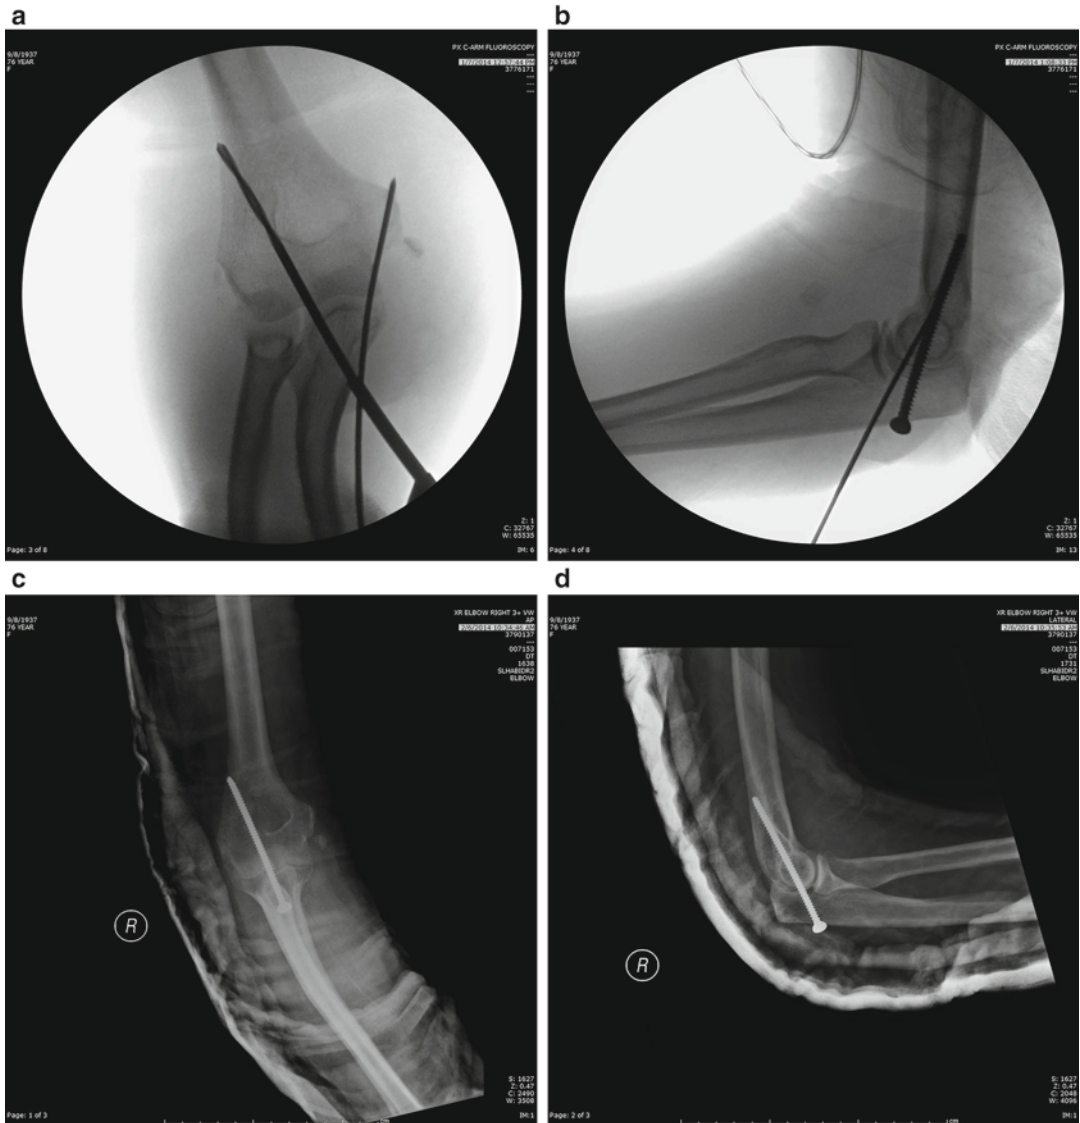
Trans-articular screw (a) Fluoroscopic intraoperative anterior–posterior (b) Fluoroscopic intraoperative lateral (c) Postoperative anterior–posterior radiograph (d) Postoperative lateral radiograph
